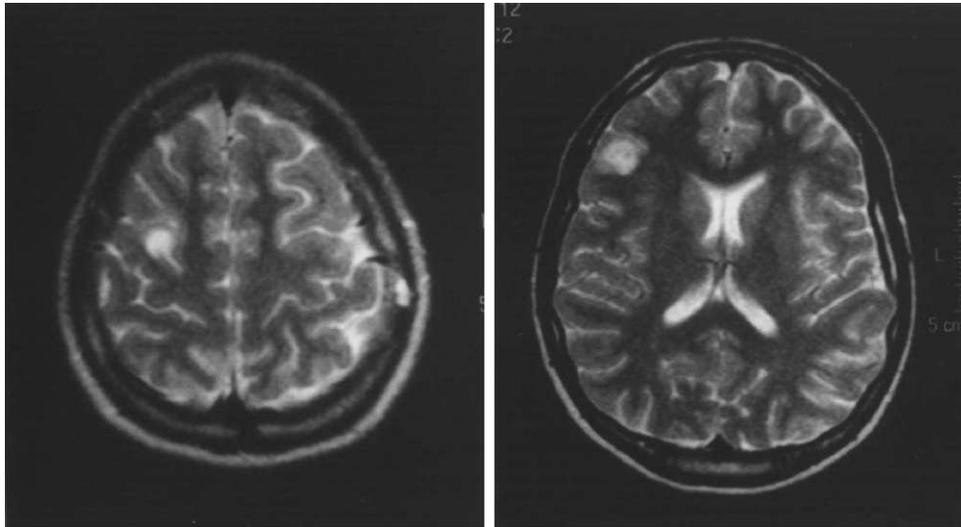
T2-weighted brain MRI reveals two large, well-defined areas of an increased bright signal without mass effect within the right frontal cortex.
